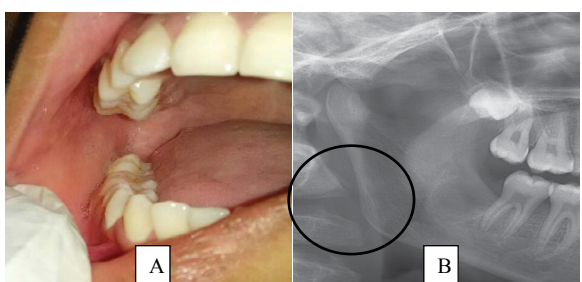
(A) Post-operative clinical photo (B) Panoramic X-ray after 12 months.
